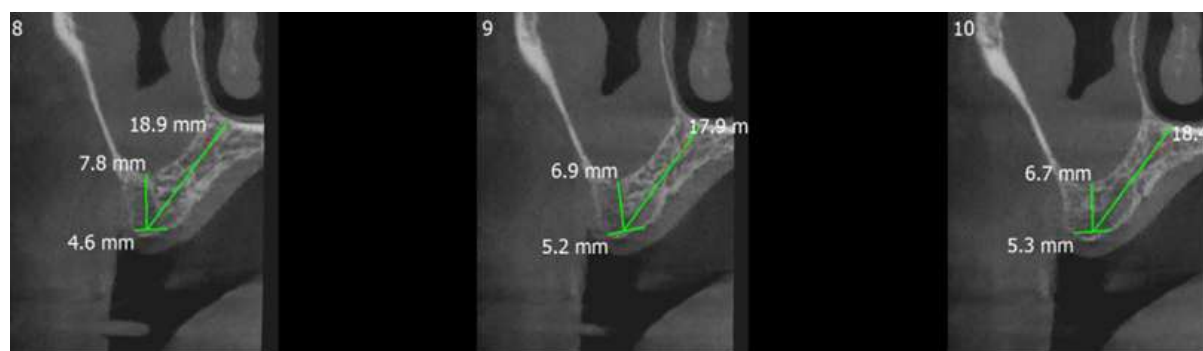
CBCT with respect to 26
